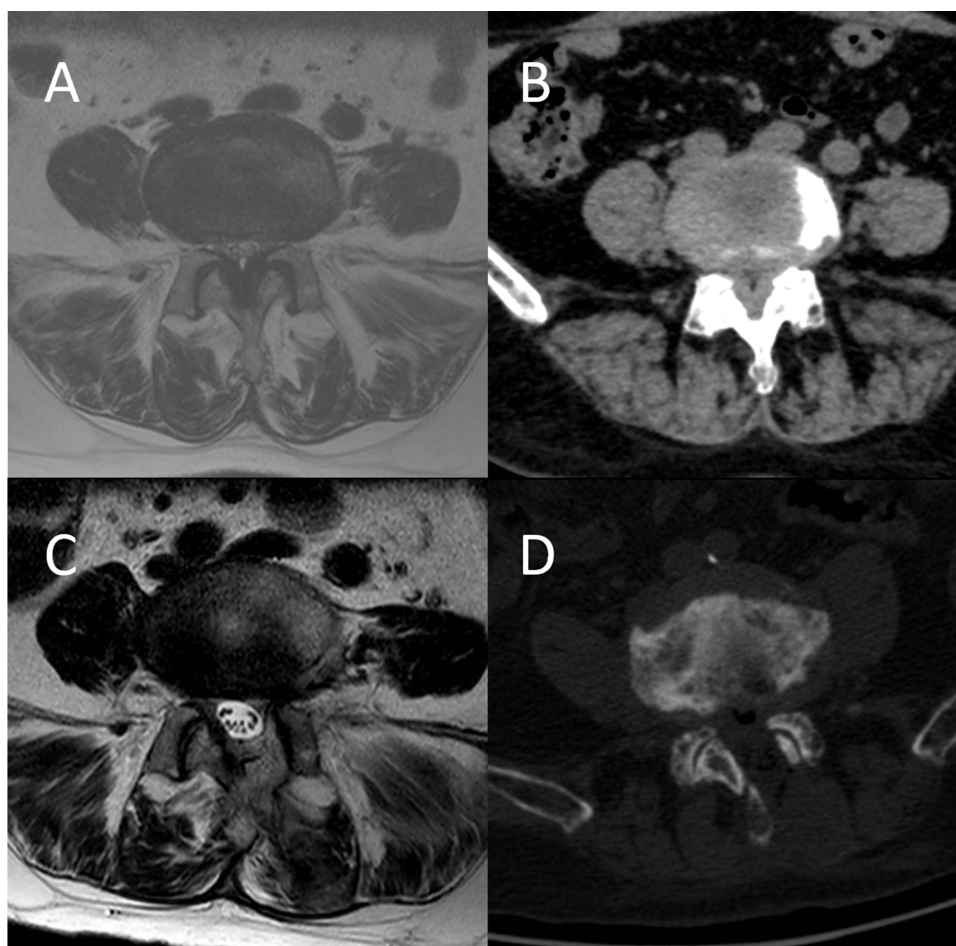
Typical case: A 75-year-old female patient complained of neurogenic claudication and was diagnosed with L4-5 degenerative lumbar spinal stenosis. (A and B) Preoperative axial MR and CT images at L4-5. (C and D) Postoperative axial MR and CT images.
